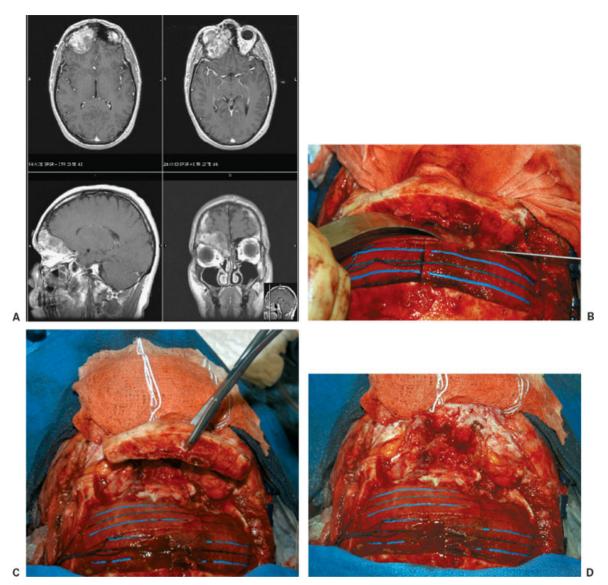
(A) Magnetic resonance images of the brain show fibrous dysplasia of the orbital bar. (B) Operative photographs show the thickened orbital bar, which has been (C) osteotomized without violation of the medial canthal ligaments (level I transbasal approach). (D) The intraorbital exposure after removal of the orbital bar.
